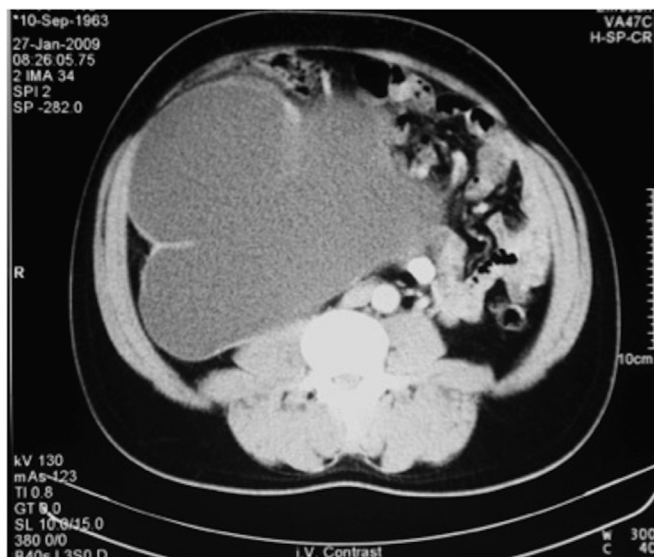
Non-contrast CT showing grossly hydronephrotic right kidney with a proximal ureteric calculus displaced across the midline.
